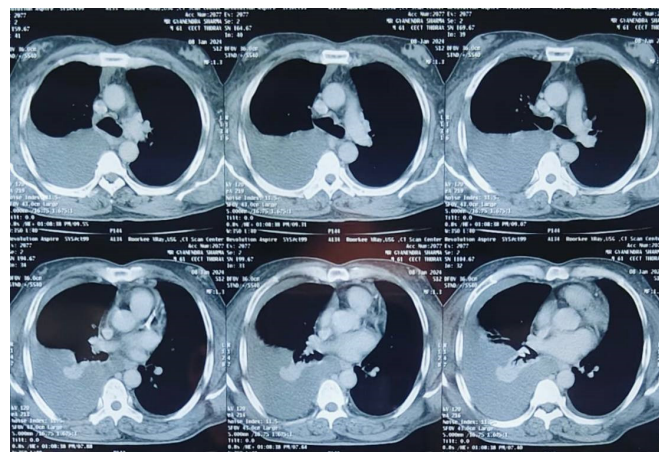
CT scan of the thorax showed right moderate to large pleural effusion and minimal left pleural effusion without parenchymal abnormality.
